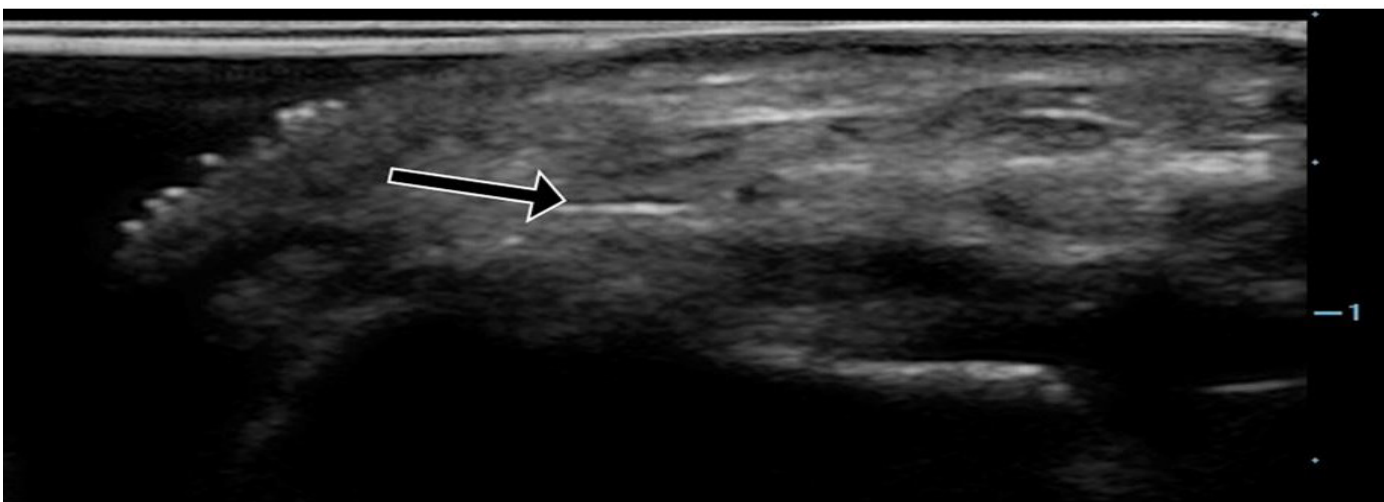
Ultrasound of the radial artery showing complete collapse with pressure applied, representing systolic pressure (arrow).
